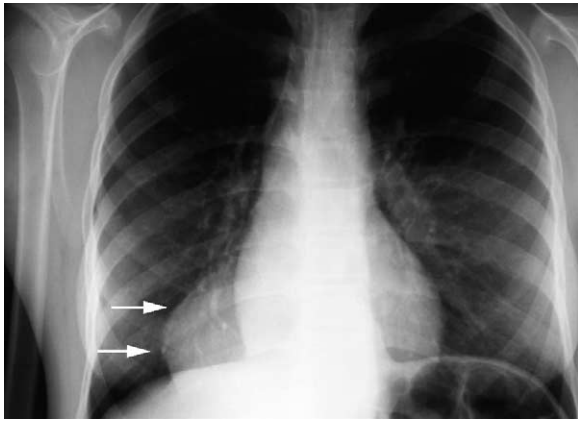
Chest radiograph of the 15-year-old girl demonstrating large mass located to the right of the cardiac border (arrows).
